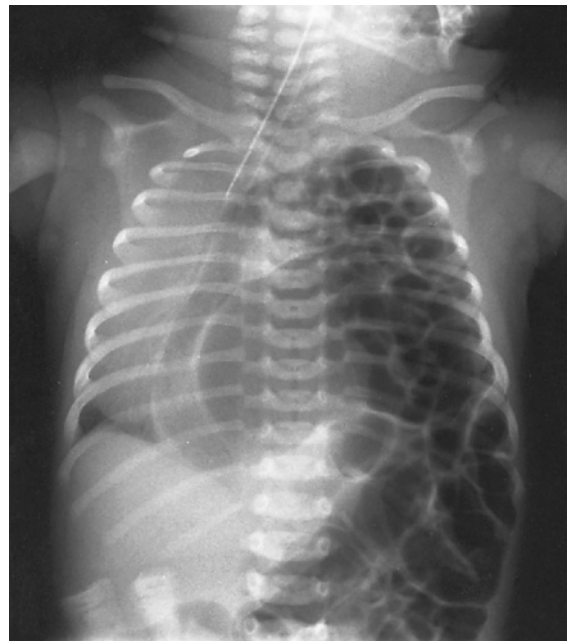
X-ray of congenital diaphragmatic hernia (Bochdalek type). Multiple bowel loops fill the left thoracic cavity and the heart is displaced to the right.
